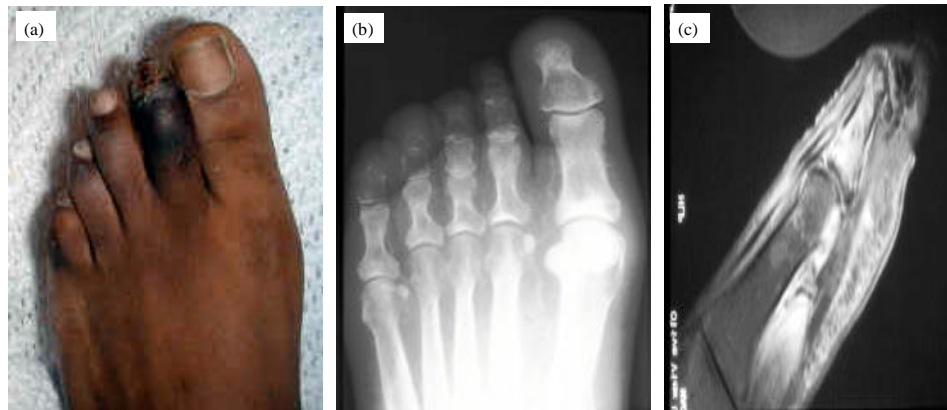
Diabetic infection of second left toe: (a) clinically, (b) plain x-ray and by (c) MRI. (Sagittal T1 weighted image with fat saturation demonstrates absent signal of the distal soft tissues and bone of the 2nd toe secondary to dry gangrene)
